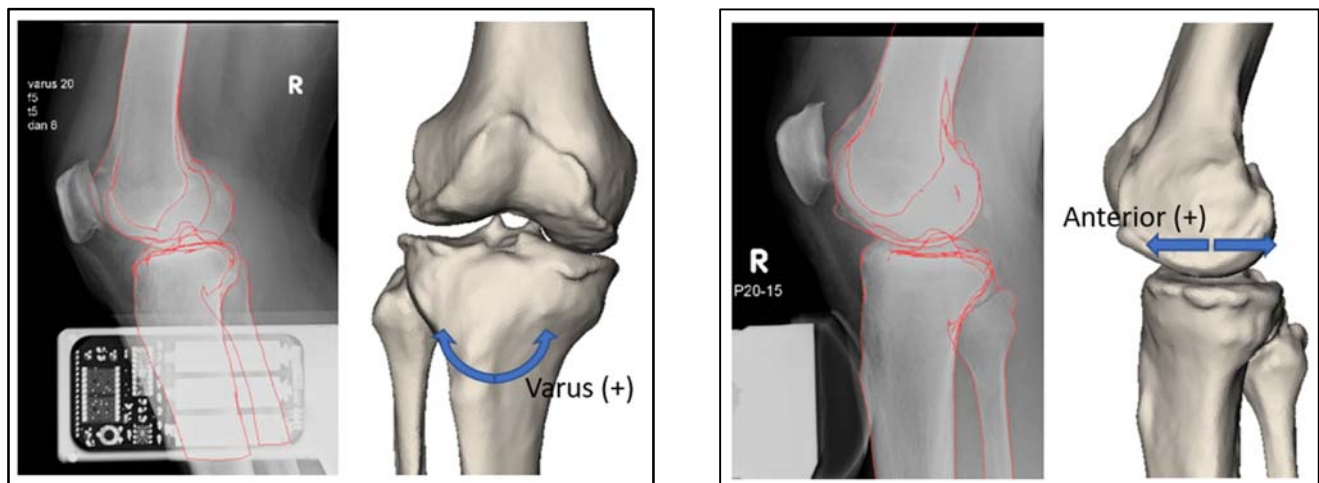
A representative of registered CT bone model to varus test and posterior test stress radiograph. Varus alignment is positive and AP position is positive when mid-point of transepicondylar axis sits anterior to the tibia centre projected to tibia sagittal plane.
